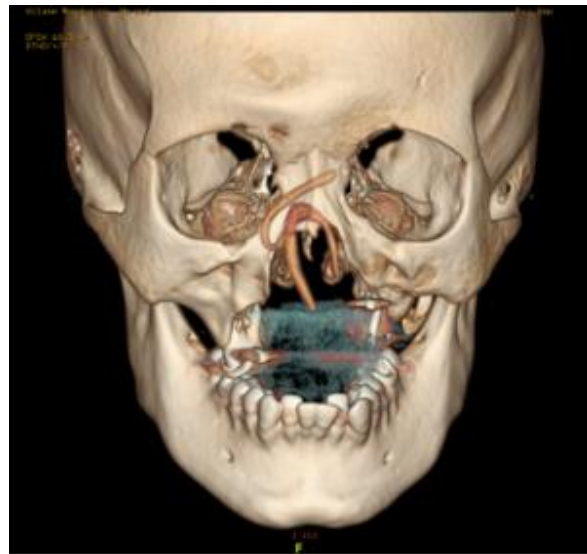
CT three dimensional reconstructions
